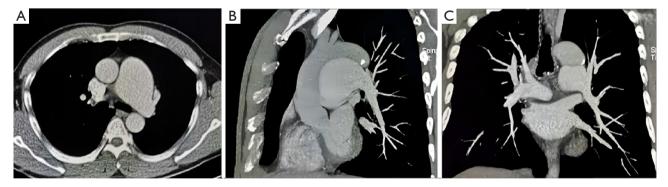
Idiopathic pulmonary hypertension in a 38-year-old male. Physical examination revealed enlargement of the pulmonary artery. The patient had a history of military service for 3 years. Follow-up for 3 years revealed no relevant clinical symptoms. (A-C) CTPA imaging and MPR reconstruction show dilation of the main and left trunk of the pulmonary artery but no dilation of the distal branch. CTPA, computed tomography pulmonary angiography; MPR, multiplanar reformation.
